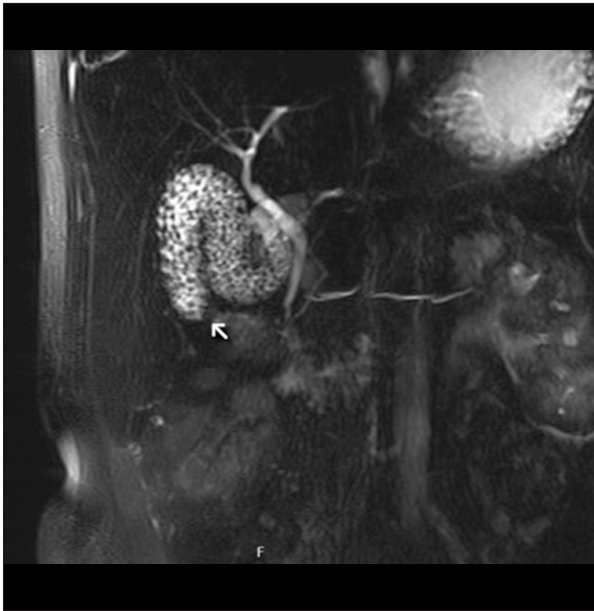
Preoperative examinations. In T2-weighted sequences, magnetic resonance cholangiopancreatography shows a Phrygian cap gallbladder (arrow) in the coronal plane with the typical twisted appearance.
